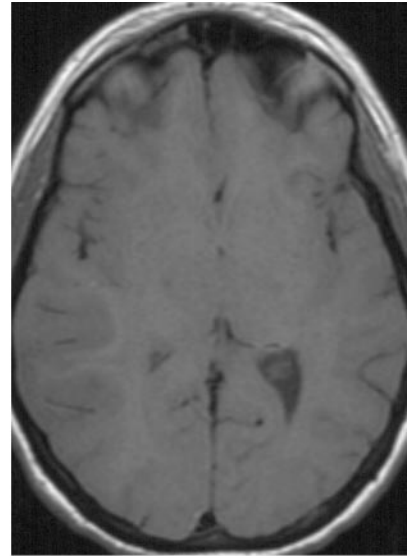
(5) Oligodendroglioma. Axial CT image shows a heavily calcified mass (arrows) in the right frontal lobe without surrounding vasogenic edema. (6) Oligodendroglioma. (a) Axial CT image shows a peripheral, ill-defined, hypoattenuating mass (arrow) in the posterior portion of the right temporal lobe. (b) Axial T1-weighted MR image shows low signal intensity of the mass. (c) Axial T2-weighted MR image shows heterogeneous high signal intensity of the mass. (d) Coronal contrast-enhanced T1-weighted MR image shows no enhancement of the mass.
